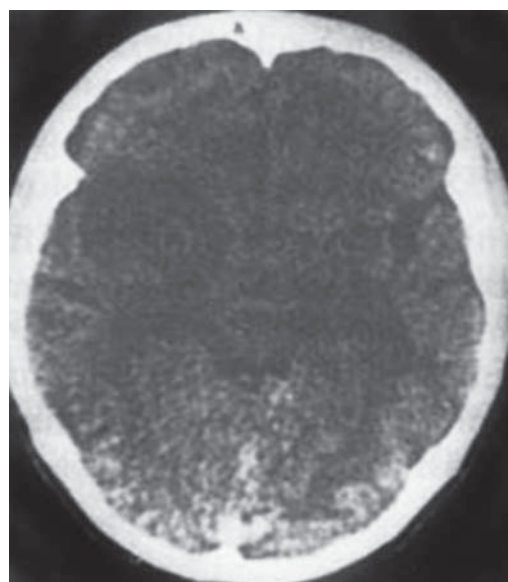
Computed tomography scan showing disseminated (diffuse) neurocysticercosis. Note the starry-night appearance.
